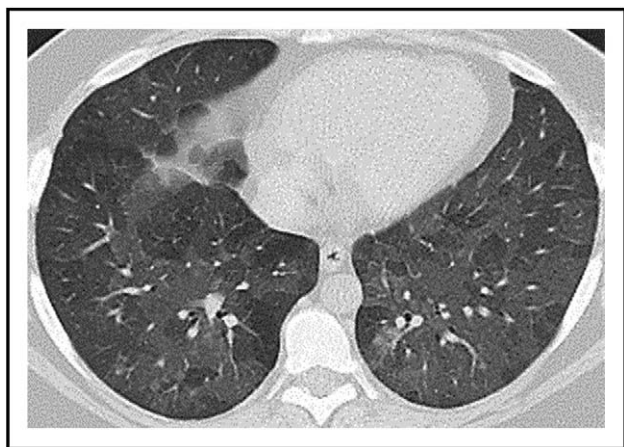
High-resolution chest computed tomography in patient with primary Sjögren's syndrome and bronchiolitis obliterans. Imaging reveals mosaic attenuation with patchwork areas of increased attenuation with lobular low attenuation suggestive of air trapping.
